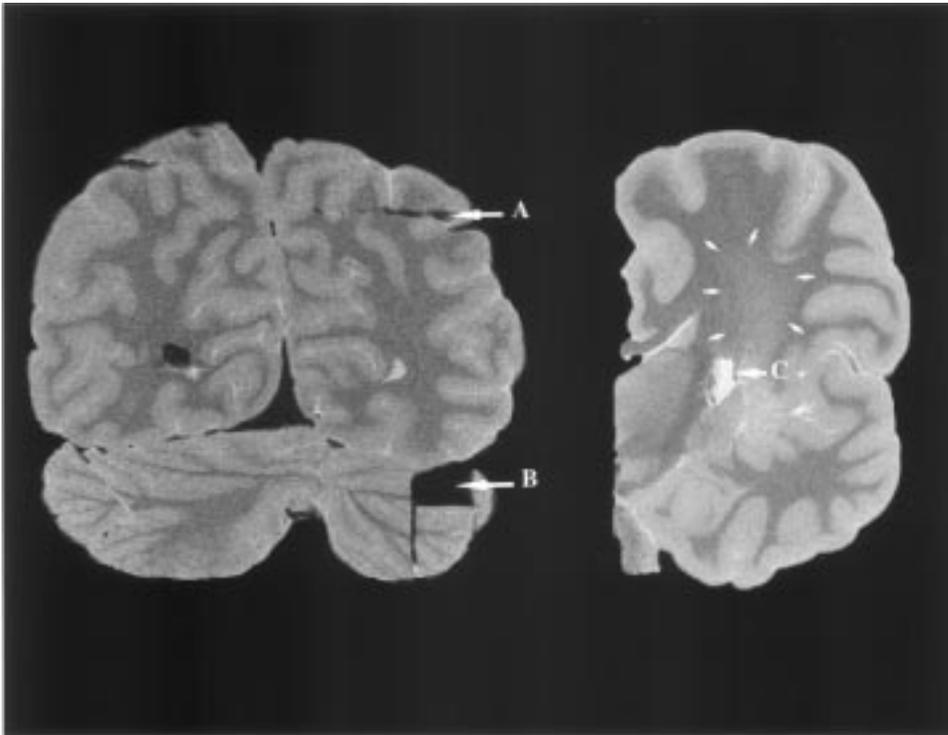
Examples of distortion commonly observed in post-mortem brains. (right) MRI coronal slice of a whole brain (male, age 44) and (left) coronal slice of a hemisphere (autistic male, age 26). Deep cuts (A) often occur during removal of the brain from the skull. Tissue sections (B) may also be removed for neuropathological examination, as seen here in the cerebellum. Insufficient fixation of brain tissue (C) may also be observed in a proton density-weighted image by abnormally bright signal intensity in deep tissue.
